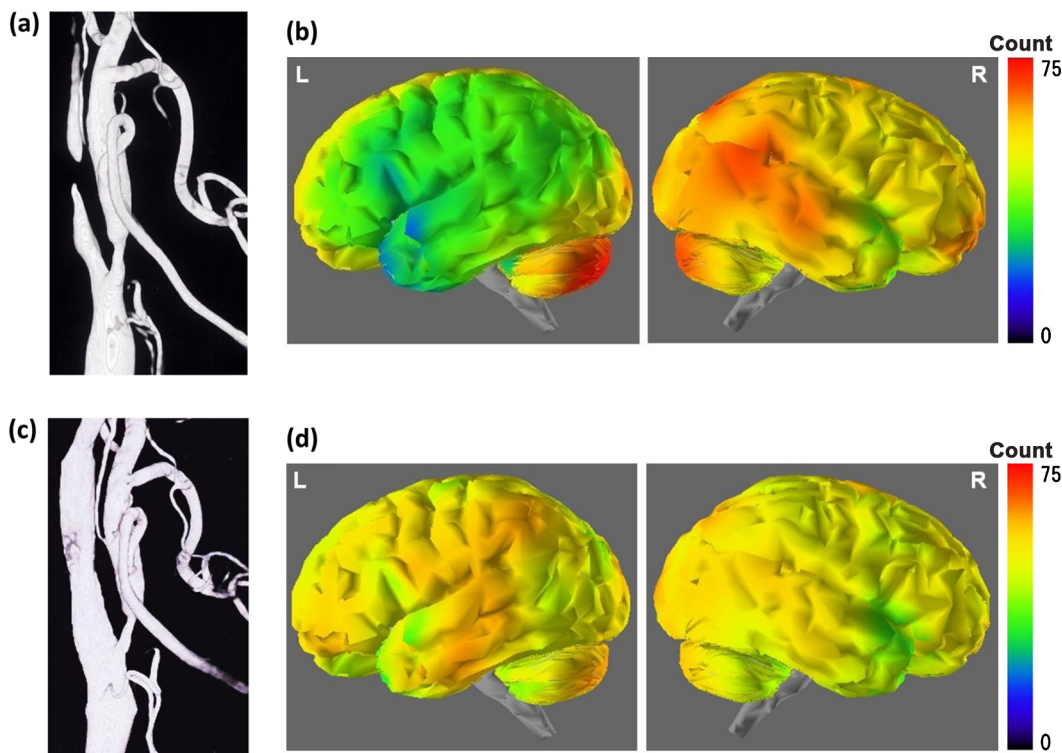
Case of cerebral ischemia (angiogram and IMP-SPECT). (a) Angiogram shows a severe stenosis of the left cervical ICA. (b) IMP-SPECT demonstrates a decrease in CBF in the area of the left MCA. (c) Angiogram shows dilation of the ICA after CAS. (d) IMP-SPECT demonstrates an increase in CBF in the area of the left MCA after CAS.
